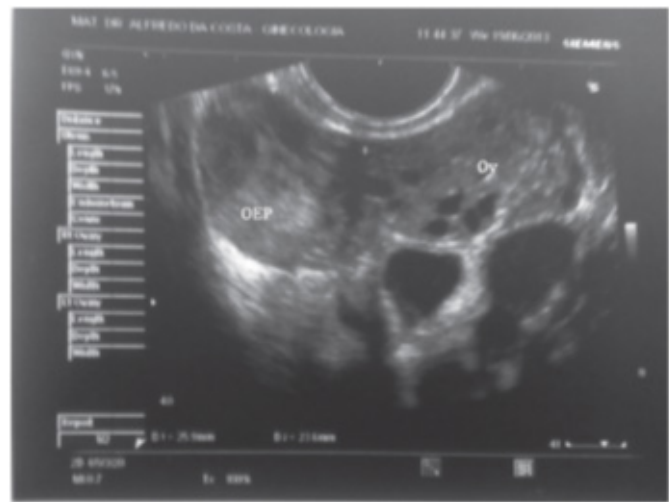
Ultrasound showing an heterogenous mass 20 mm adjacent to the ovary (OEP, ovarian ectopic pregnancy; Ov, ovary).
